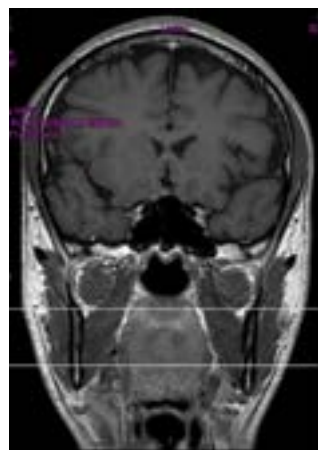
(A) Postoperative MRI (coronal view) and (B) angiography at the second year of follow-up and 1 year after radiotherapy (for the left vagal paraganglioma) shows complete tumor removal on the right side while the size of the left sided tumor size remains unchanged.
